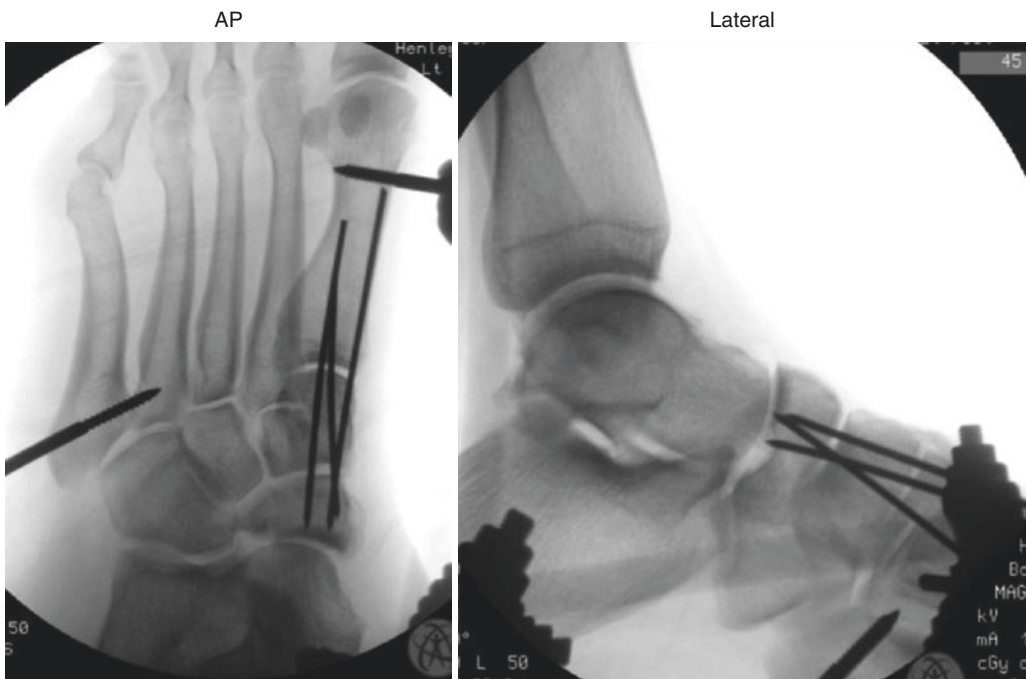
Radiographs demonstrating percutaneous fixation following closed reduction of the navicular. External fixation pins are also seen
